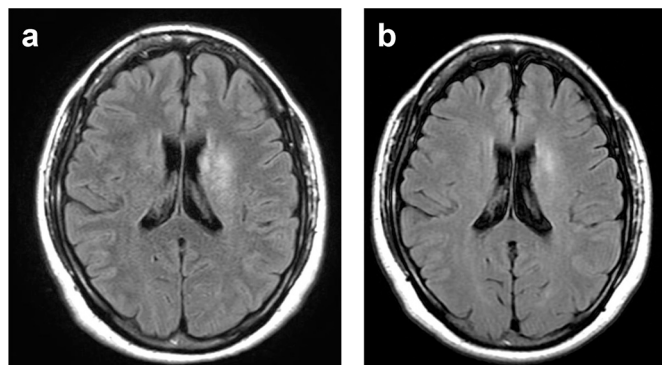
MRI of the head: a) MRI showed T2-prolonged lesions in the left basal ganglia. There was no brain atrophy. b) MRI 8 months after therapy showed improvement of the T2-prolonged lesions in the left basal ganglia.
